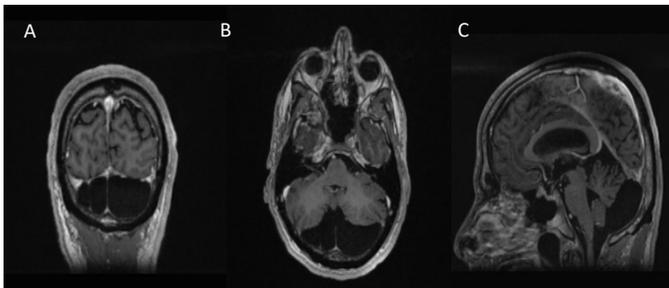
(A) Coronal, (B) Axial, and (C) Sagittal views of pre-operative MRI.
